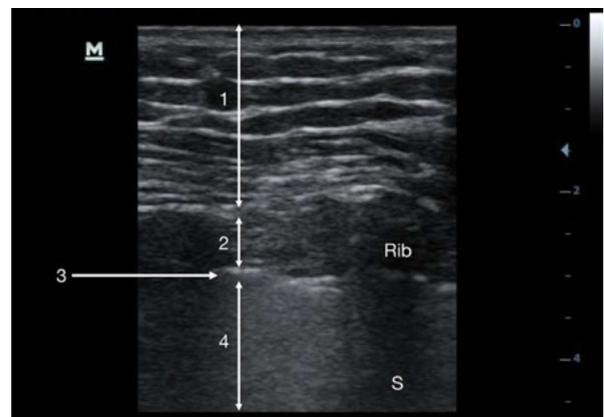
Chest wall in ultrasound: 1) Skin, fat, and muscle. 2) Ribs and intercostal muscles. 3) Pleural line. 4) Lung. S) Acoustic shadow from the rib.)
